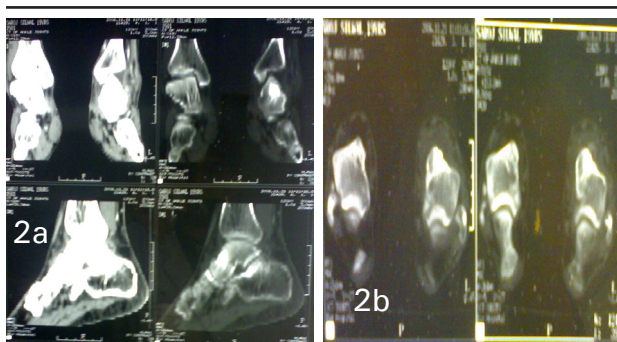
2a. CT scan Sagittal Cut. 2b. CT scan Coronal cut
